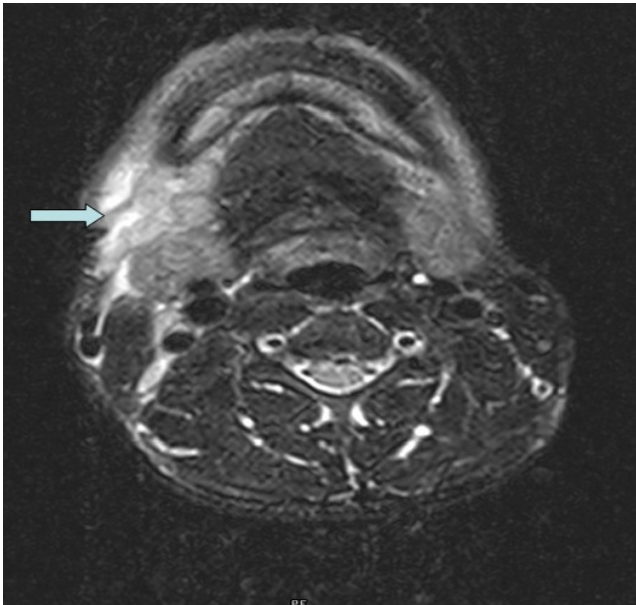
Axial T₂ weighted MR image shows a solid lesion and surrounding minimal fluid intensity.
